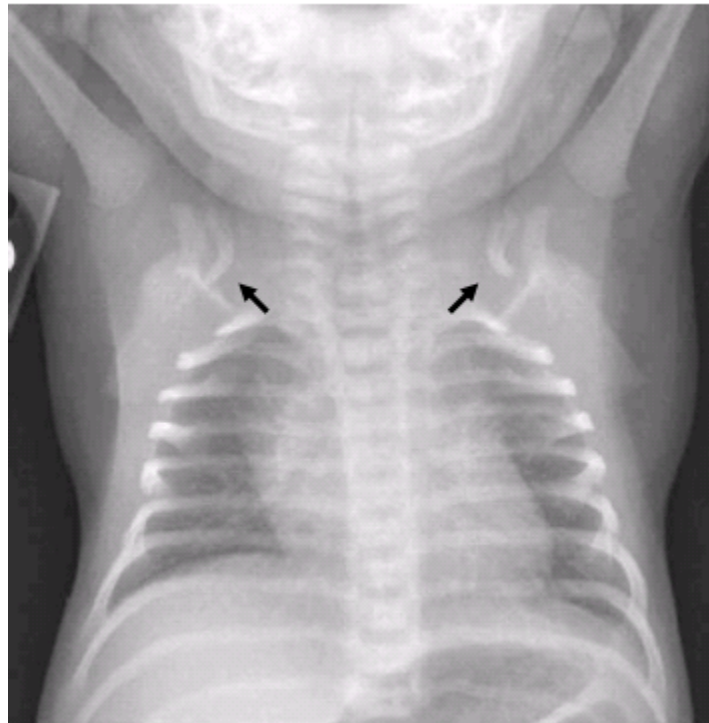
Chest x-ray demonstrates clavicular hypoplasia.
